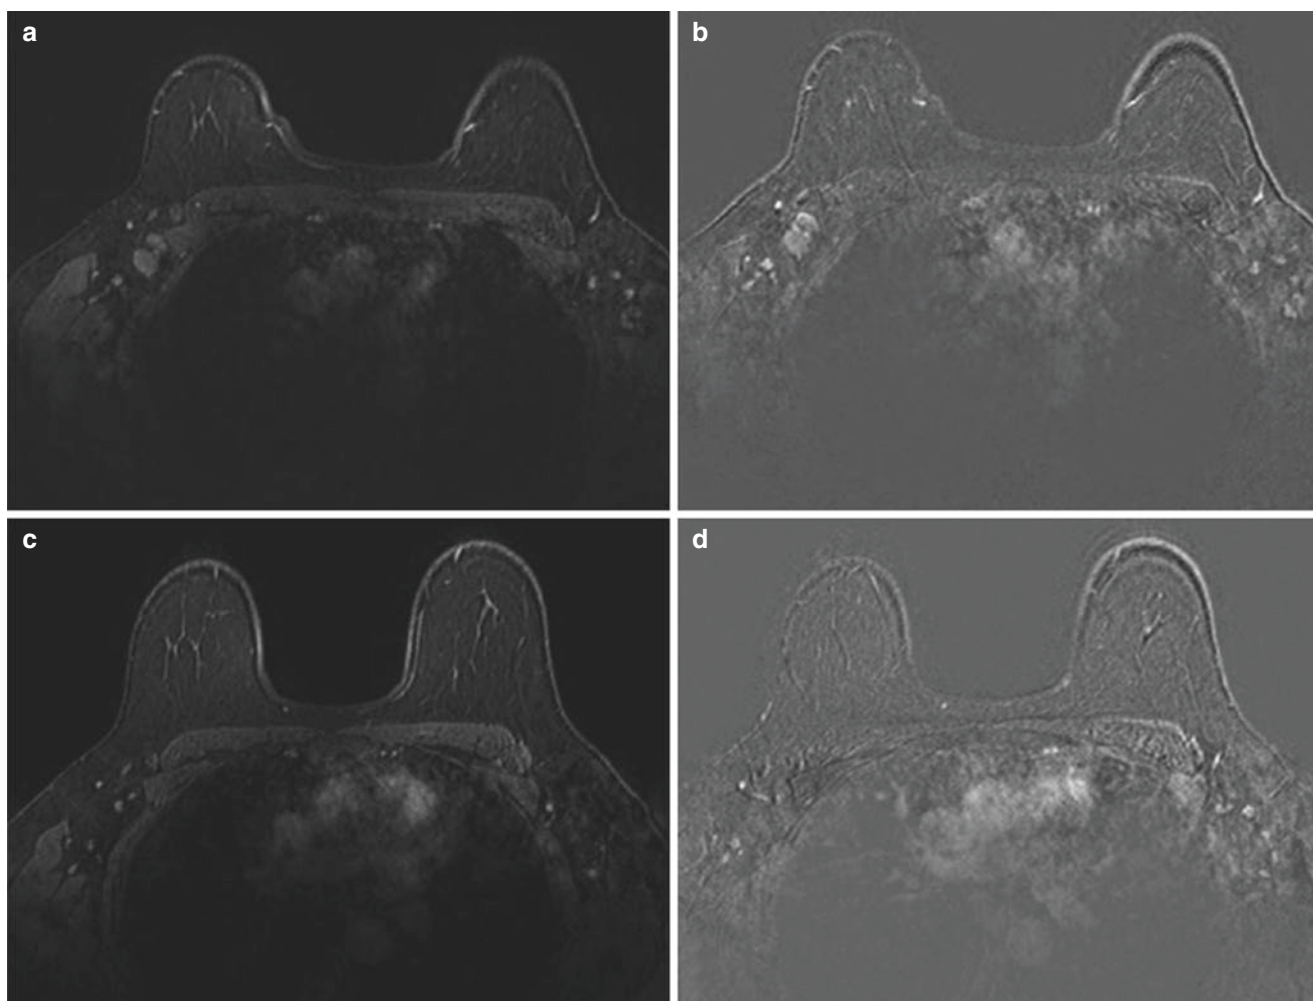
Magnetic resonance imaging of positive lymph nodes before (a, b) and after (c, d) PST with complete pathological response
